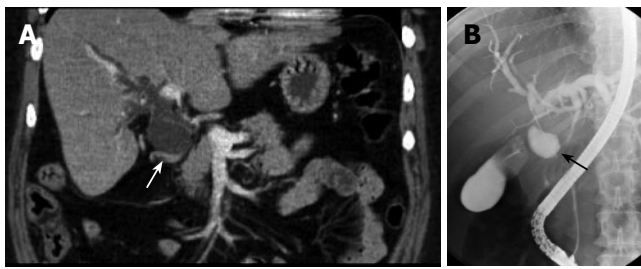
Abdominal coronal CT-scan showing dilated intrahepatic bile ducts and common bile duct (arrow) (A), ERCP showing filling of a cystic lesion (arrow) connected to the common bile duct, initially diagnosed as a duplicate gallbladder or choledochal cyst (B) in case 4.
